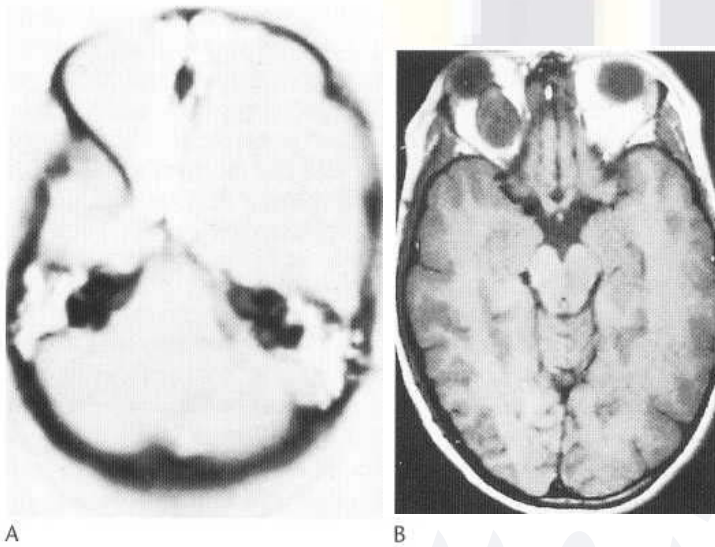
(A) Neurofibromatosis showing absence of sphenoid wing on the right. Reversal negative at wider window for bone detail. (B) Axial MRI (T₁-weighted) shows right optic nerve glioma as low-signal rounded mass in a patient with neurofibromatosis.
